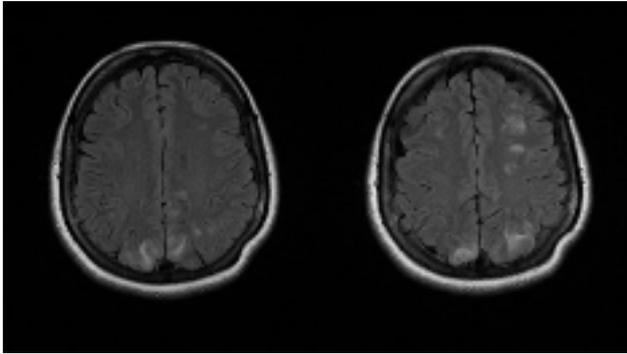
Magnetic resonance imaging revealed bilateral hyperintense lesions in subcortical white matter of occipital lobes on T2-FLAIR sequences.
